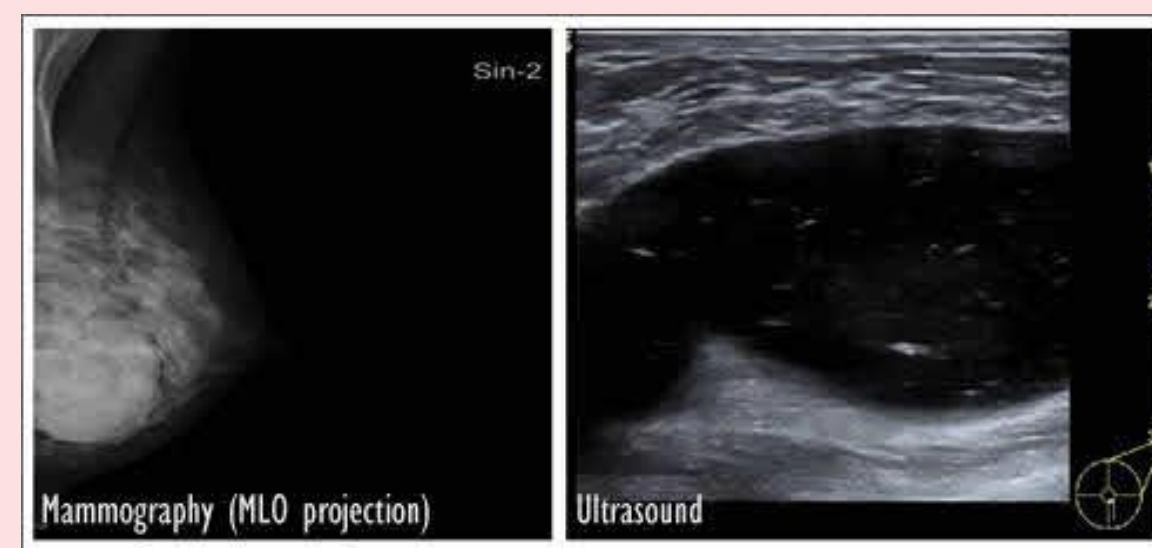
Mammography shows increased density and Ultrasound displays 'Sparkly lake sign'.
